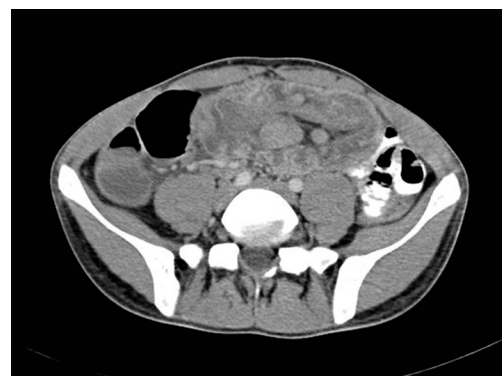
Computed tomography image of intussusception at midline with multiple lymphadenopathies.
